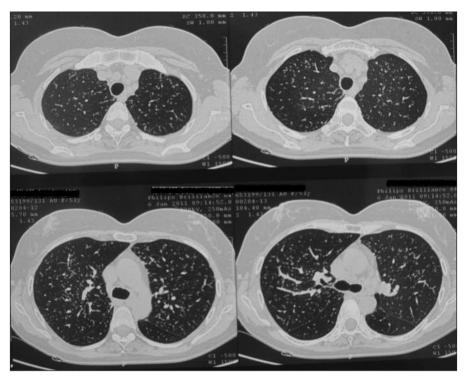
Computed tomography at presentation shows extended micronodules and interlobular and interlobular septal thickenings.
